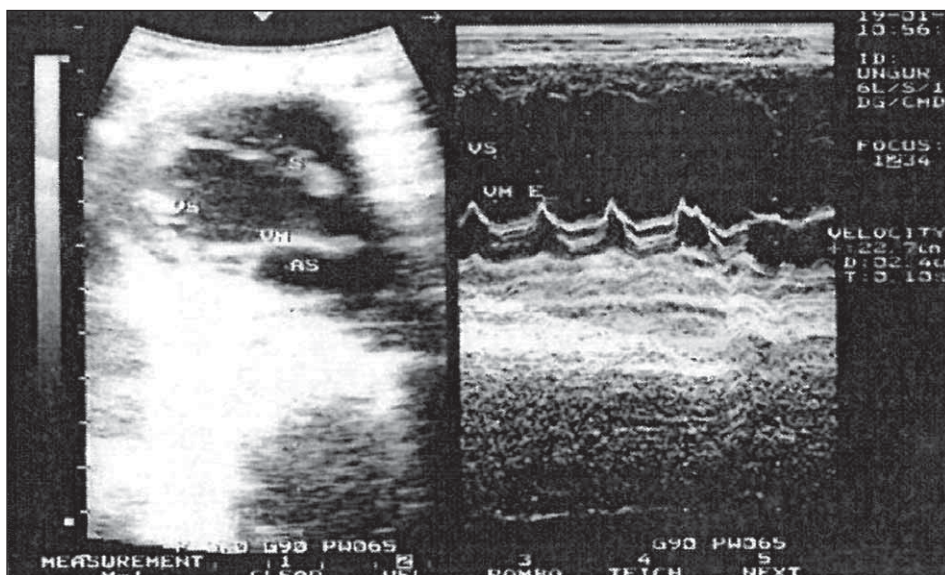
Echocardiographic aspect: Aorta: 1.1 cm, Left atrium: 1.6 cm, Left ventricle: 3.4/3.8 cm, mitral valve close to the posterior wall of the left ventricle with "fish-mouth"-shaped orifice, limited septal-to-posterior wall motion, FE: 0.24, FS: 11%, mitral E-septum distance: 2.4 cm. Diagnostic: dilated cardiomyopathy
